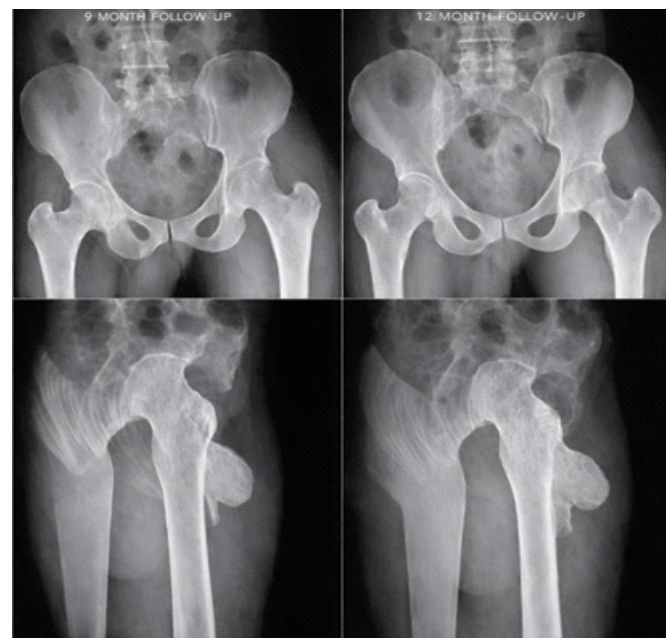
9 and 12-month follow-up X-rays.
